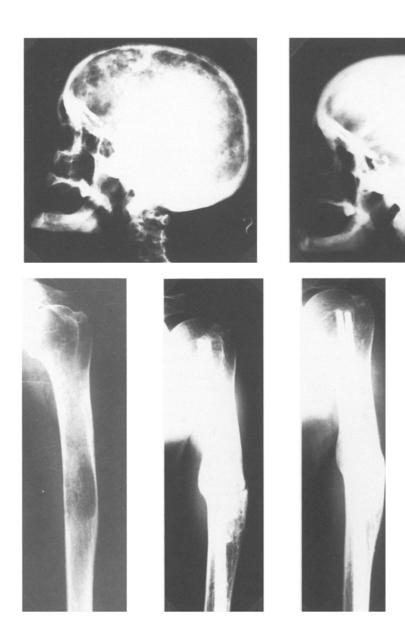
X-rays obtained in two patients, showing complete recalcification of a skull metastases (*I*, before treatment; 2, after therapy) and b humerus lesions (*I*, before treatment; 2, during treatment; 3, after therapy), respectively. In the latter case, fixation of the humerus was performed due to a pathological fracture before the chemotherapy was started
